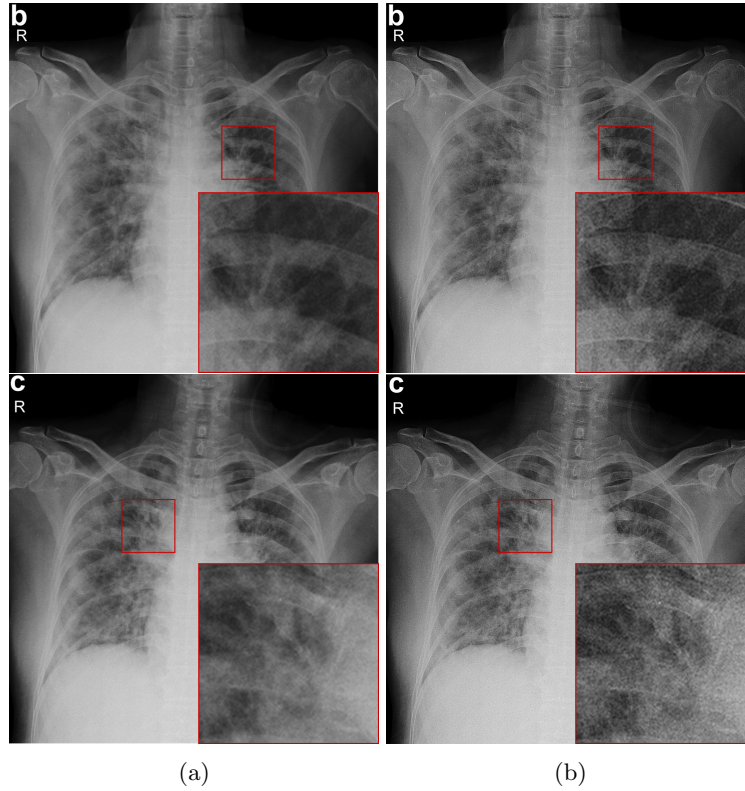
COVID-19 chest X-ray. (a) Samples from COVIDx dataset; (b) Images after enhancement on (a).
